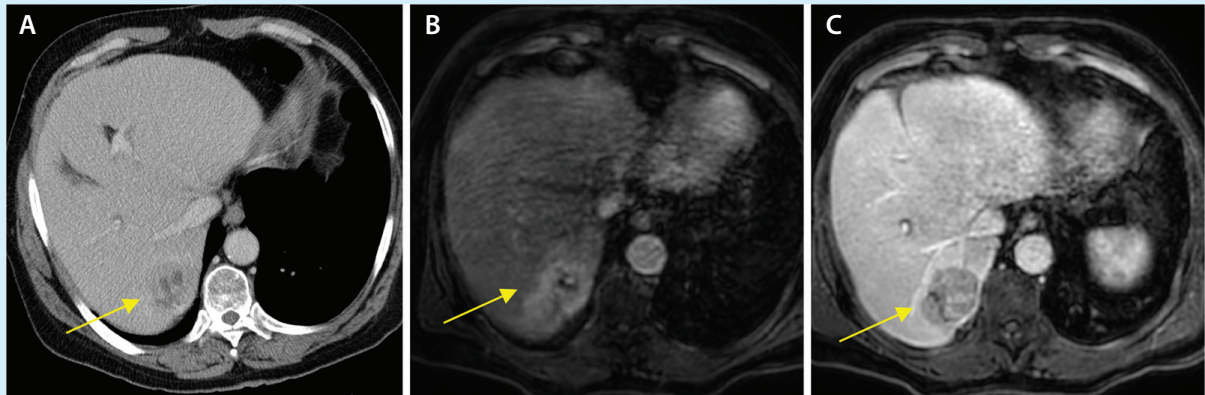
Contrast-enhanced CT (A) and MRI images show a segment 7 mass (arrows) with arterial enhancement (B) and venous washout (C).
